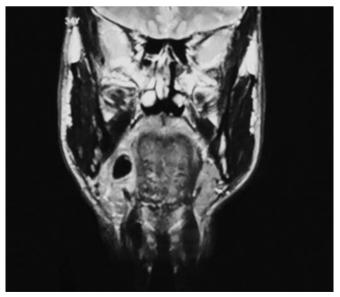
Coronal MRI of the right submandibular gland.
